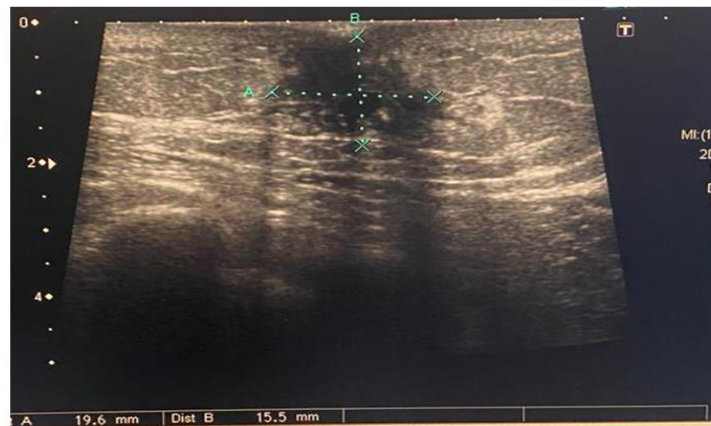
Breast ultrasound showed a lesion around 1.9 * 1.5 cm.
